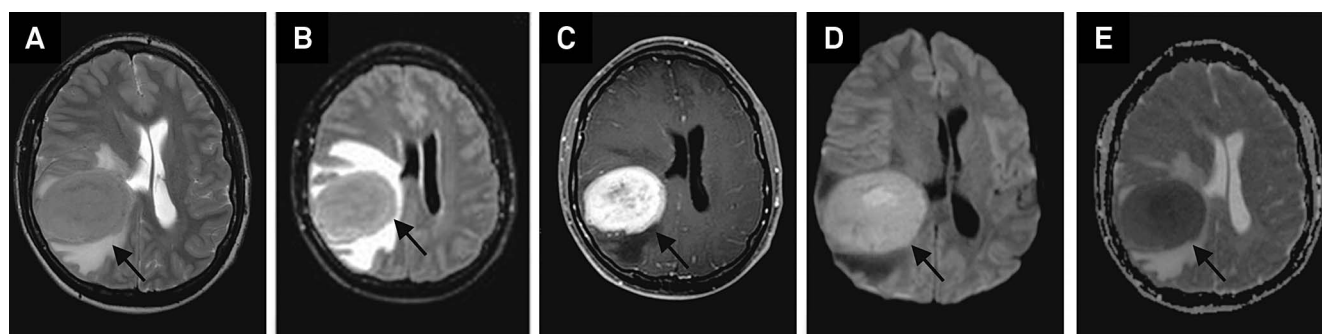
(A) Magnetic resonance imaging (MRI) shows an intra-axial right parietal solid lesion, isointense on T2 weighted image; (B) With edema and mass effect seen on FLAIR; (C) MRI T1 weighted image post contrast shows a heterogeneous enhancement hyperintense in (D) diffusion weighted imaging and (E) hypointense in ADC map, characterizing restricted diffusion.
